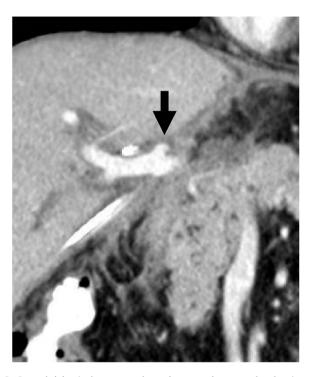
Coronal abdominal contrast-enhanced computed tomography, showing portal pseudoaneurysm at the reconstructed portion (arrow).
